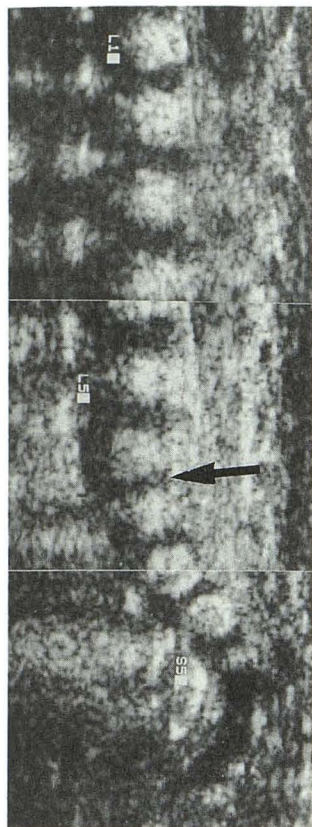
Miscalculation in an early study of a patient with four ossified sacral vertebral bodies. Although the LSJ is well seen (arrow), it was not recognized, probably because of the expectation that five ossified sacral vertebral bodies should be present. The most caudal ossification center, believed to be the fifth sacral vertebral body (S-5), is actually the fourth. Counting upward, the fourth lumbar vertebral body is erroneously labeled L-5 and the twelfth thoracic vertebral body is erroneously labeled L-1. Four sacral ossified vertebral bodies were seen on a lateral plain film of the vertebral column.
